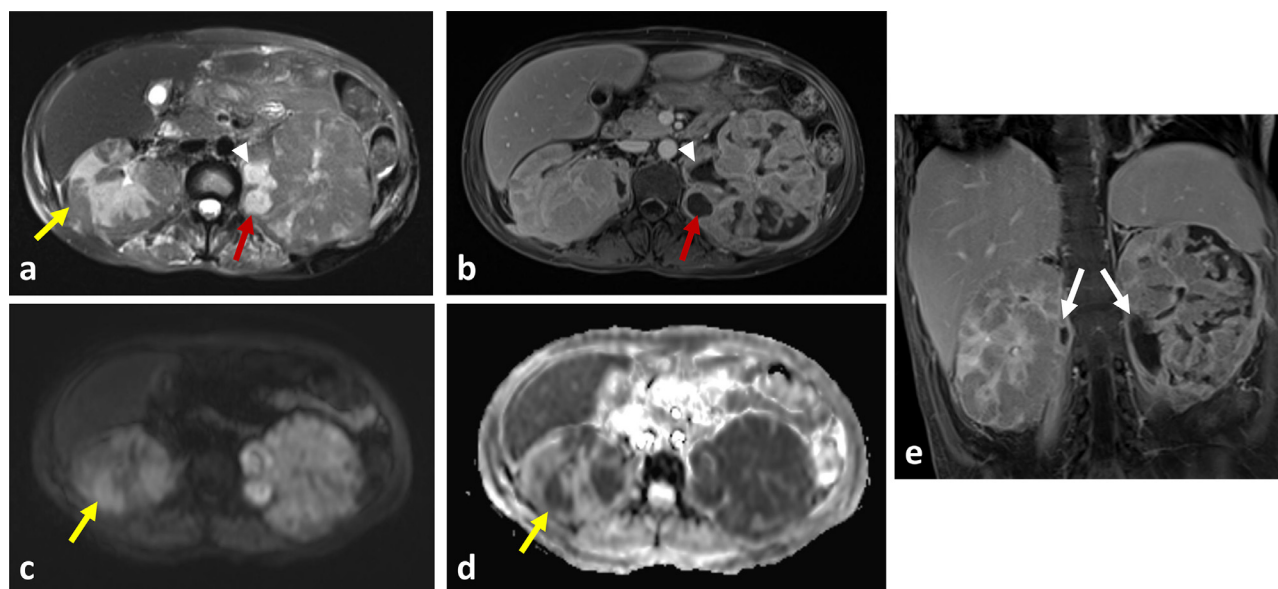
Axial T2-weighted (a) and T1 post-contrast (b) images of the abdomen demonstrate bilateral nephromegaly with heterogeneous hypoenhancement and signal intensity in the left greater than right kidney. Bilateral intrarenal and perinephric fluid collections are also present (red arrows). Mild left hydronephrosis with thickening of the left renal pelvis is also present (arrowheads), as well as thickening of the left perinephric fascia and retroperitoneal soft tissues. Diffusion-weighted images (c) and corresponding ADC map (d) demonstrate diffusion restriction in the areas of parenchymal hypoenhancement (yellow arrows). Coronal post-contrast images (e) demonstrate fluid collections extending into both psoas muscles (white arrows).
